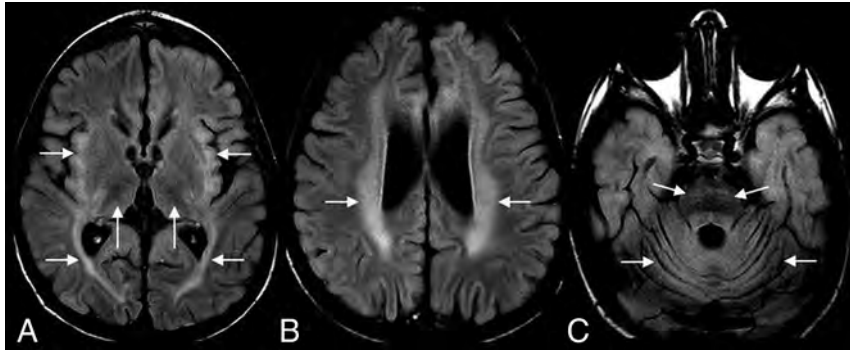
A 4-year-old boy with CLN2 disease. Axial FLAIR MR imaging shows hypointense thalami and hyperintense insular/subinsular region and posterior limb of the internal capsule (A); hyperintense periventricular and deep white matter (B), and hyperintense ventral pons (C). Note diffuse cerebral and cerebellar volume loss (A–C).
